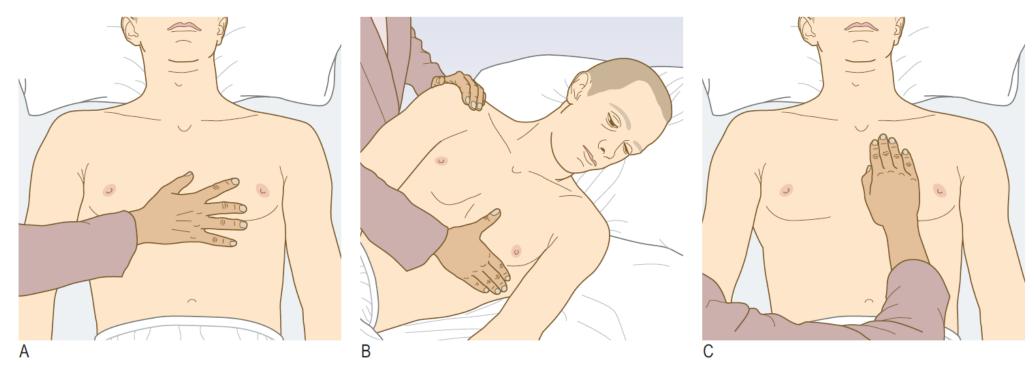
Palpating the heart. A Use your hand to palpate the cardiac impulse. B Localise the apex beat with your finger (if necessary, roll the patient into the left lateral position). C Palpate from apex to sternum for parasternal pulsations.
